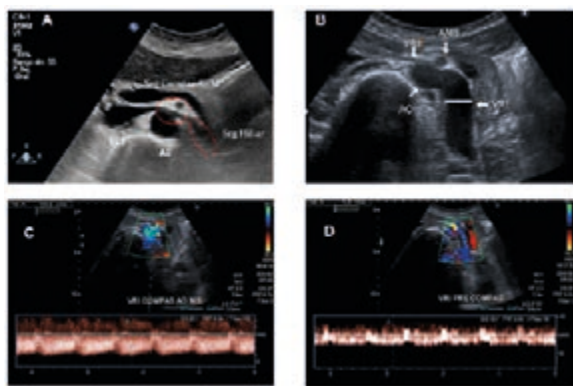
A) Cross-sectional view at normal epigastrium level showing the 2 segments (red circles), the trajectory of the LRV where peak velocity and diameter are measured. AO, abdominal aorta; IVC, inferior vena cava. B) NCS, LRV dilatation in the hilar LRV segment and significant caliber reduction at AMC level. SMA, superior mesenteric artery. C and D) Measurements of velocity with spectral Doppler in the compressed (AMC) and hypoflow regions (hilar segment).
